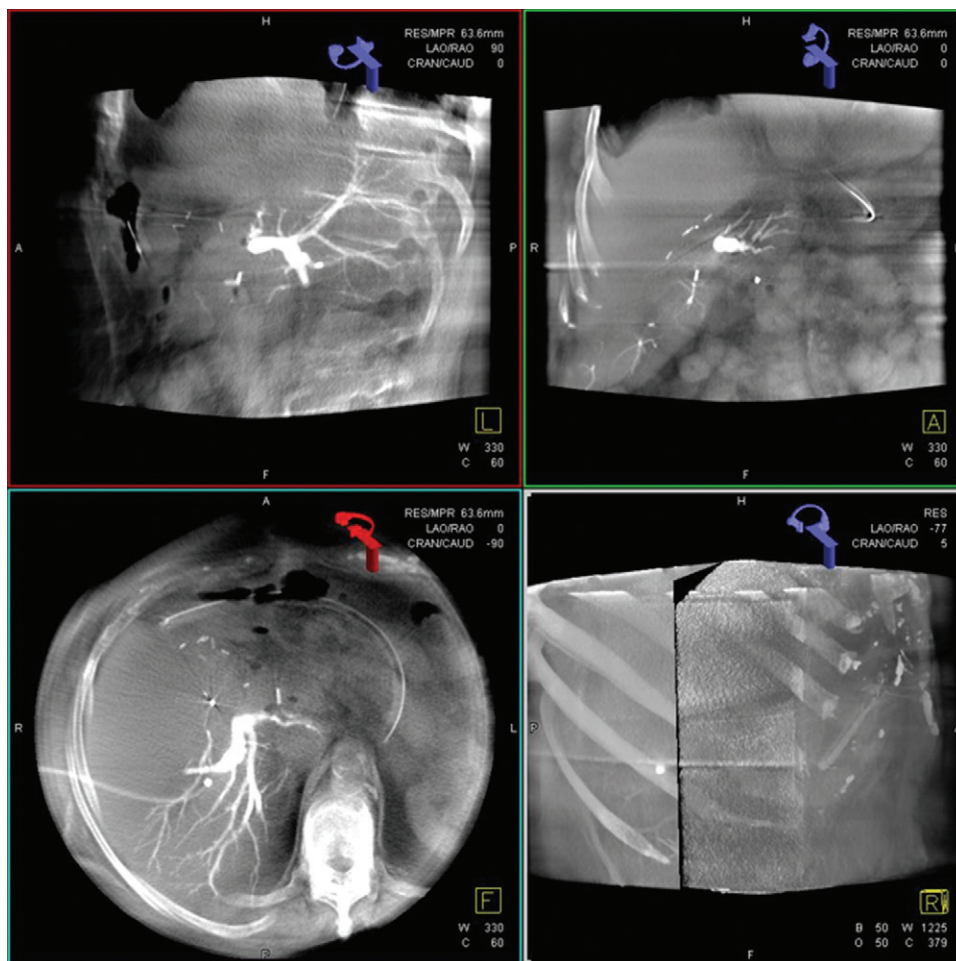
Intraprocedural three-dimensional reconstructed cone-beam CT images show occlusion of the right posterior hepatic duct; however, posterior ducts were communicating with caudate lobe ducts. Percutaneous reconstruction was not possible because of the acute angle of the reconstruction path. Surgical biliary enteric anastomosis was performed by using caudate lobe ducts.
